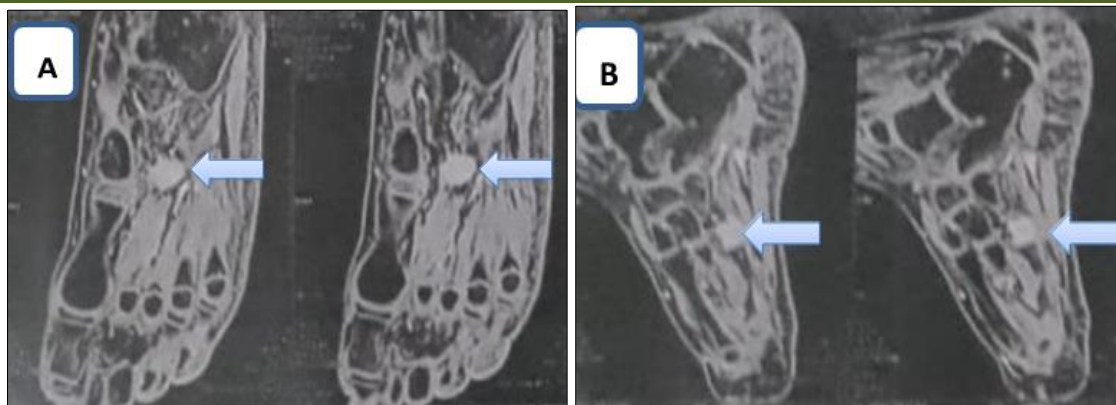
(A) Axial and (B) sagittal magnetic resonance imaging showing a lesion in the deep plantar soft tissues of the left foot without signs of aggressiveness, in intimate contact with the plantaris quadratus muscle, and encompassing the tendon of the peroneus longus muscle
